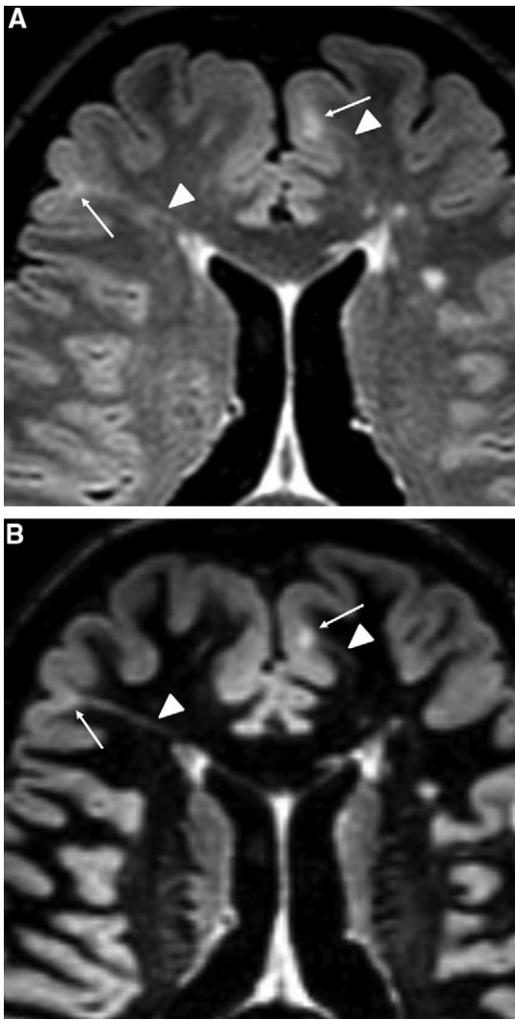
A 44-year-old woman with TSC examined using 3D FLAIR and 3D DIR imaging. (A) 3D FLAIR and (B) 3D DIR images show the presence of cortical tubers (arrows A and B). The cortical tubers are more clearly delineated on the 3D DIR image than on the 3D FLAIR image (arrows A and B). Radially oriented white matter bands are also depicted more clearly on the 3D DIR image than on the 3D FLAIR image (arrowheads A and B).
